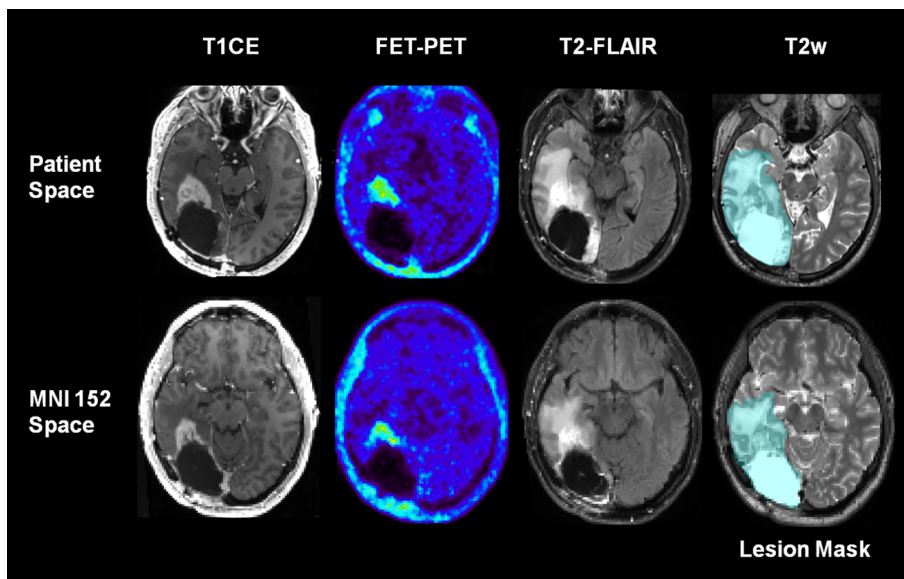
Essential image pre-processing steps. A multimodal lesion mask comprising residual or recurrent tumor and all treatment-related tissue changes in any of the structural MRI and FET-PET images was manually outlined and used for cost-function masking of the elastic registration of all structural and functional images to the MNI standard space. In this patient, a resection cavity, a perifocal zone of abnormal high T2-signal, a FET PET-positive recurrence, and edema are present. T1CE: T1-weighted MR image with contrast enhancement, T2w: T2-weighted SPACE MR image, T2-FLAIR: Fluid Attenuated Inversion Recovery MR image, FET-PET: O-(2-[¹⁸F]fluoroethyl)-L-tyrosine Positron-Emission-Tomography.
